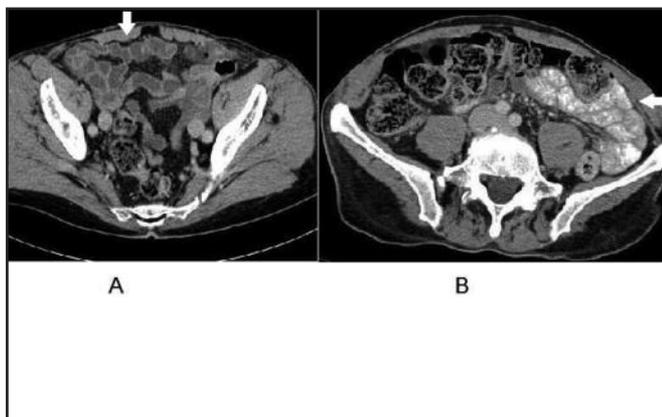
Selected coronal CT images of a 77-year-old male patient with water (A) and gastrografin (B) as OC show comparable bowel wall delineation in the jejunum (arrows) with either OC agent.
